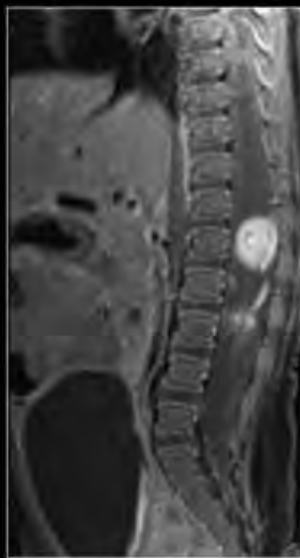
Contrast-enhanced sagittal T1-weighted image of the lumbar spine demonstrates pathology-proven conus infantile hemangioma.
